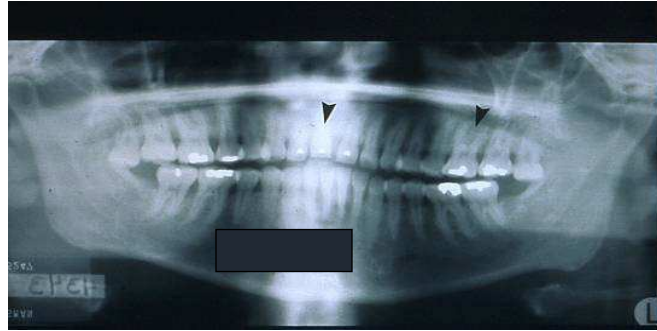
38-year-old female severe periodontitis, uncontrolled diabetes type 2, radiographs.
